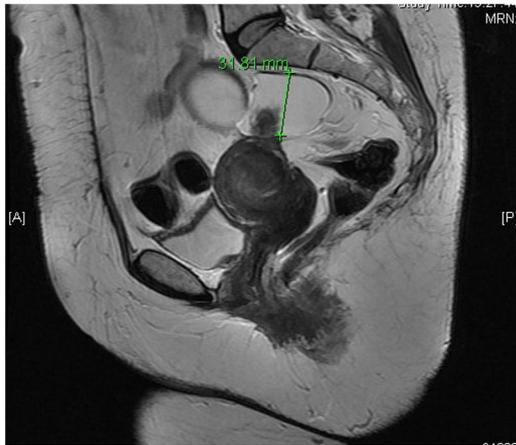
Sagittal section T2 magnetic resonance image.
